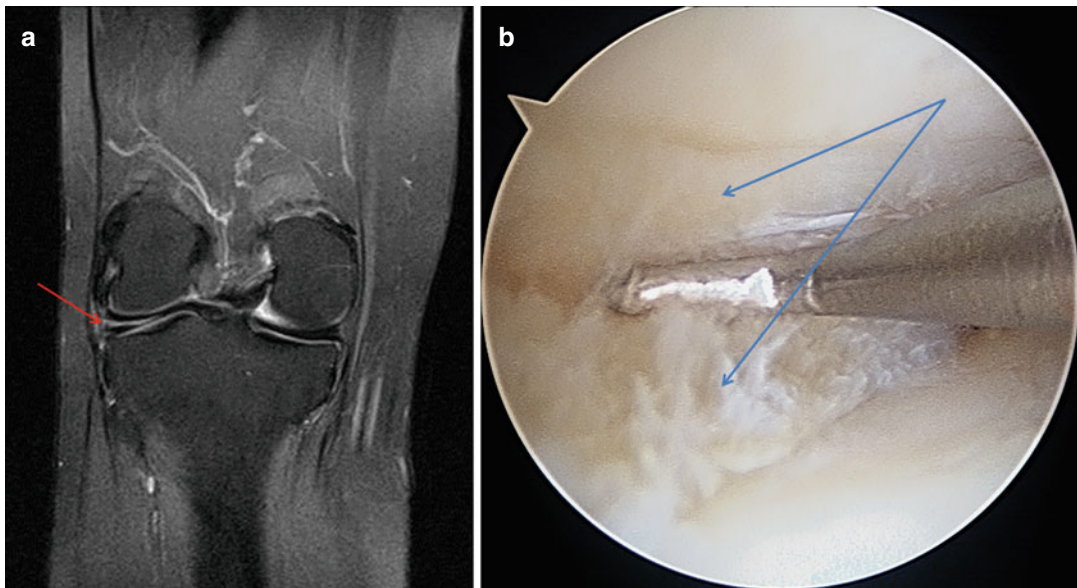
Horizontal cleavage tear on MRI (a) and arthroscopic view (b) demonstrating the superior and inferior components of the tear (blue arrows)
